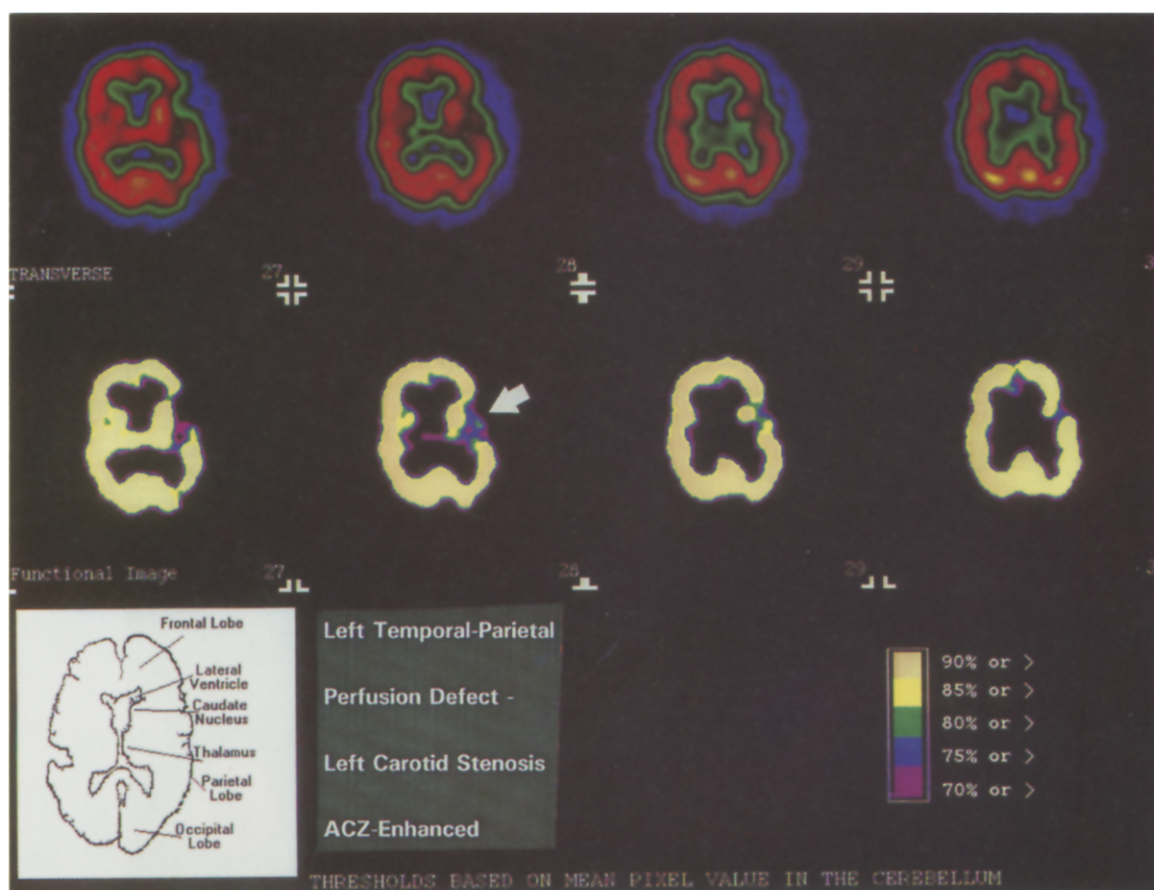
SPECT SCAN - ACZ enhancement. Preoperative (L) cortical perfusion defect (Ischemia).
